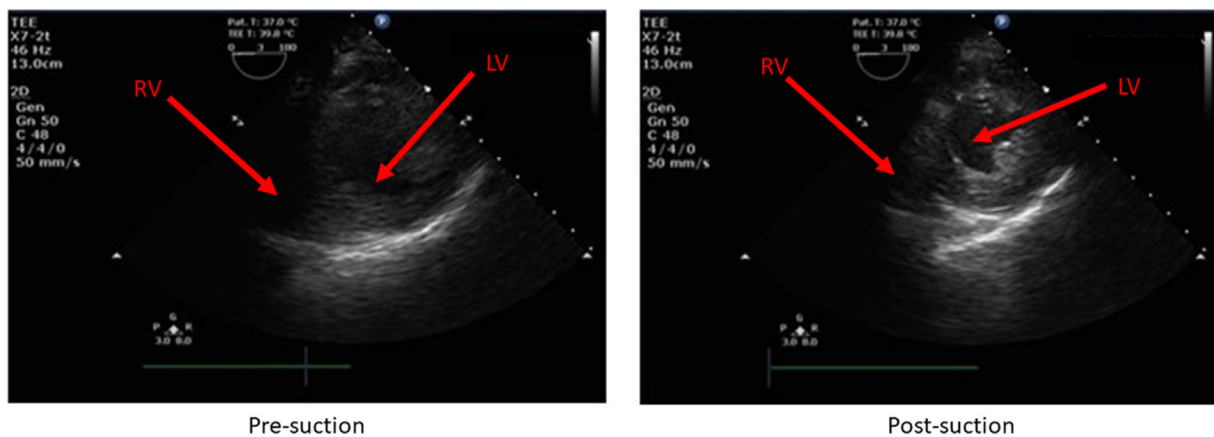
Transesophageal echocardiography image quality improvement with suctioning orogastric tube. Note that echocardiography setting stayed the same before and after suctioning
